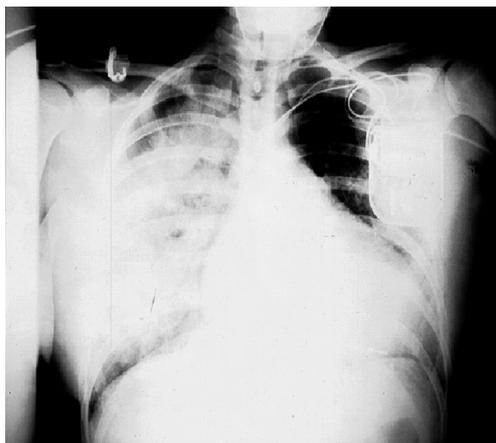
Chest X-ray performed on the day of acute dyspnea revealing the presence of a right-sided pulmonary edema with a diffuse infiltrate.
